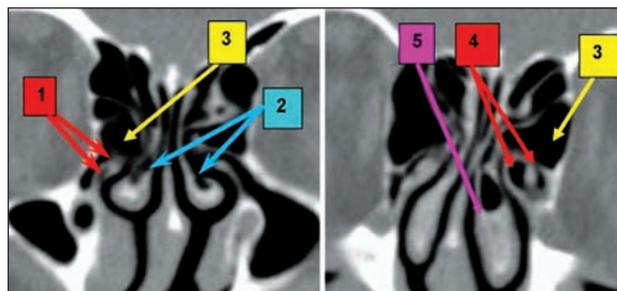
Paranasal sinuses CT scan, bone window, consecutive coronal slices: 1. right uncinete process pneumatization, adherent to the ethmoid bulla; 2. bilateral concha bullosa; 3. giant right ethmoid bulla; 4. left uncinete process pneumatization, adherent to giant ethmoid bulla; 5. left concha bullosa. N.B. Corroborating data from this case show a bilateral pneumatization of the uncinete process and bilateral concha bullosa, but at different levels
